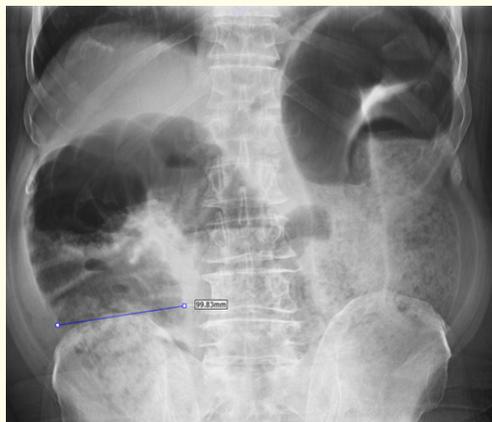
The air fluid level on abdominal X-ray.
